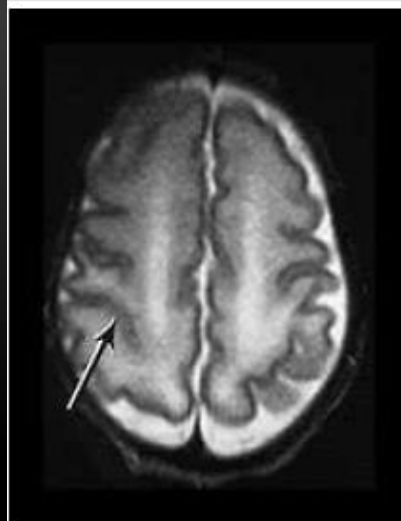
Representative MRI of the three grades of abnormality in gray matter gyral maturation in the premature infants on MRI at term: A, grade 1 with normal gyral maturation at term; B, grade 2 demonstrating a reduction in complex gyral folding but secondary gyri in the transverse sulci and gyri consistent with 36 to 37 weeks' gestational age; and C, grade 3 demonstrating severe impairment in gyral development in all regions consistent with 34 weeks' gestational age.
